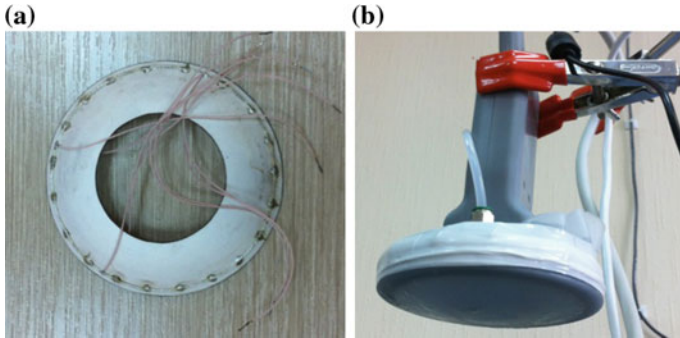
Focusing piezoelement (a) and assembled HIFU ultrasonic transducer (b)
